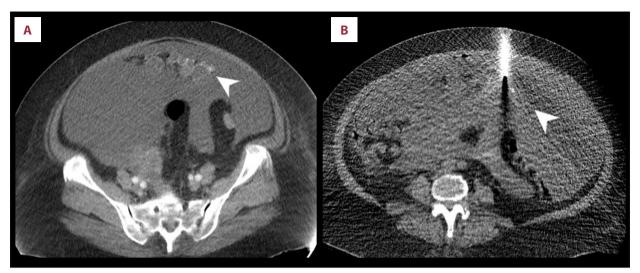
Omental caking (white arrow head) along the greater omentum is seen anteriorly with surrounding ascites on contrast-enhanced CT at presentation (A), which was subsequently biopsied with an 18-gauge needle under CT guidance (B).
